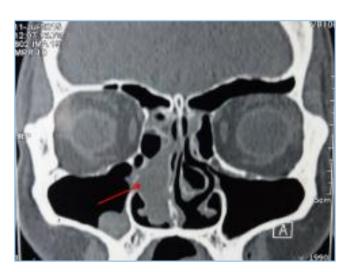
CT Scan showing Right Nasal Mass
